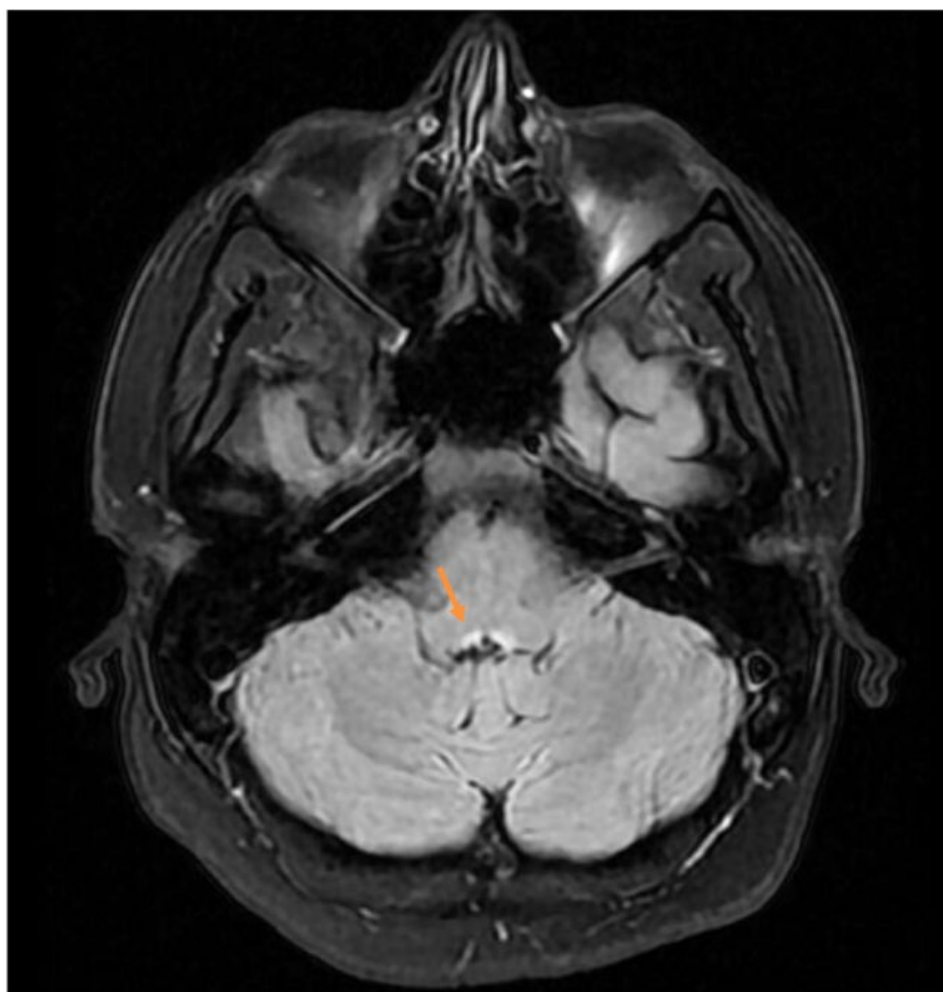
Magnetic resonance imaging (MRI) FLAIR of brain: bilateral hyperintensity in the periaqueductal region suggesting a metabolic lesion (arrow).
